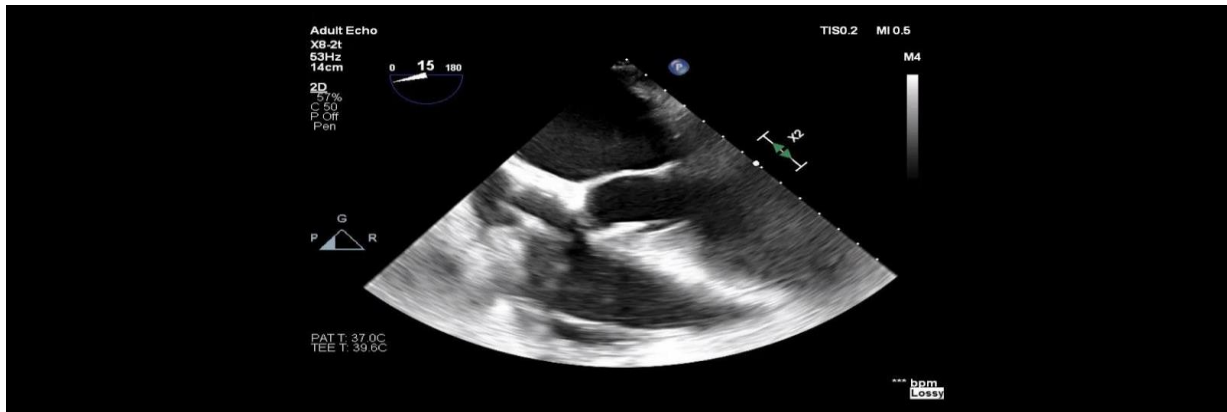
Transthoracic Echocardiography showing echodensity attached to the ICD.
